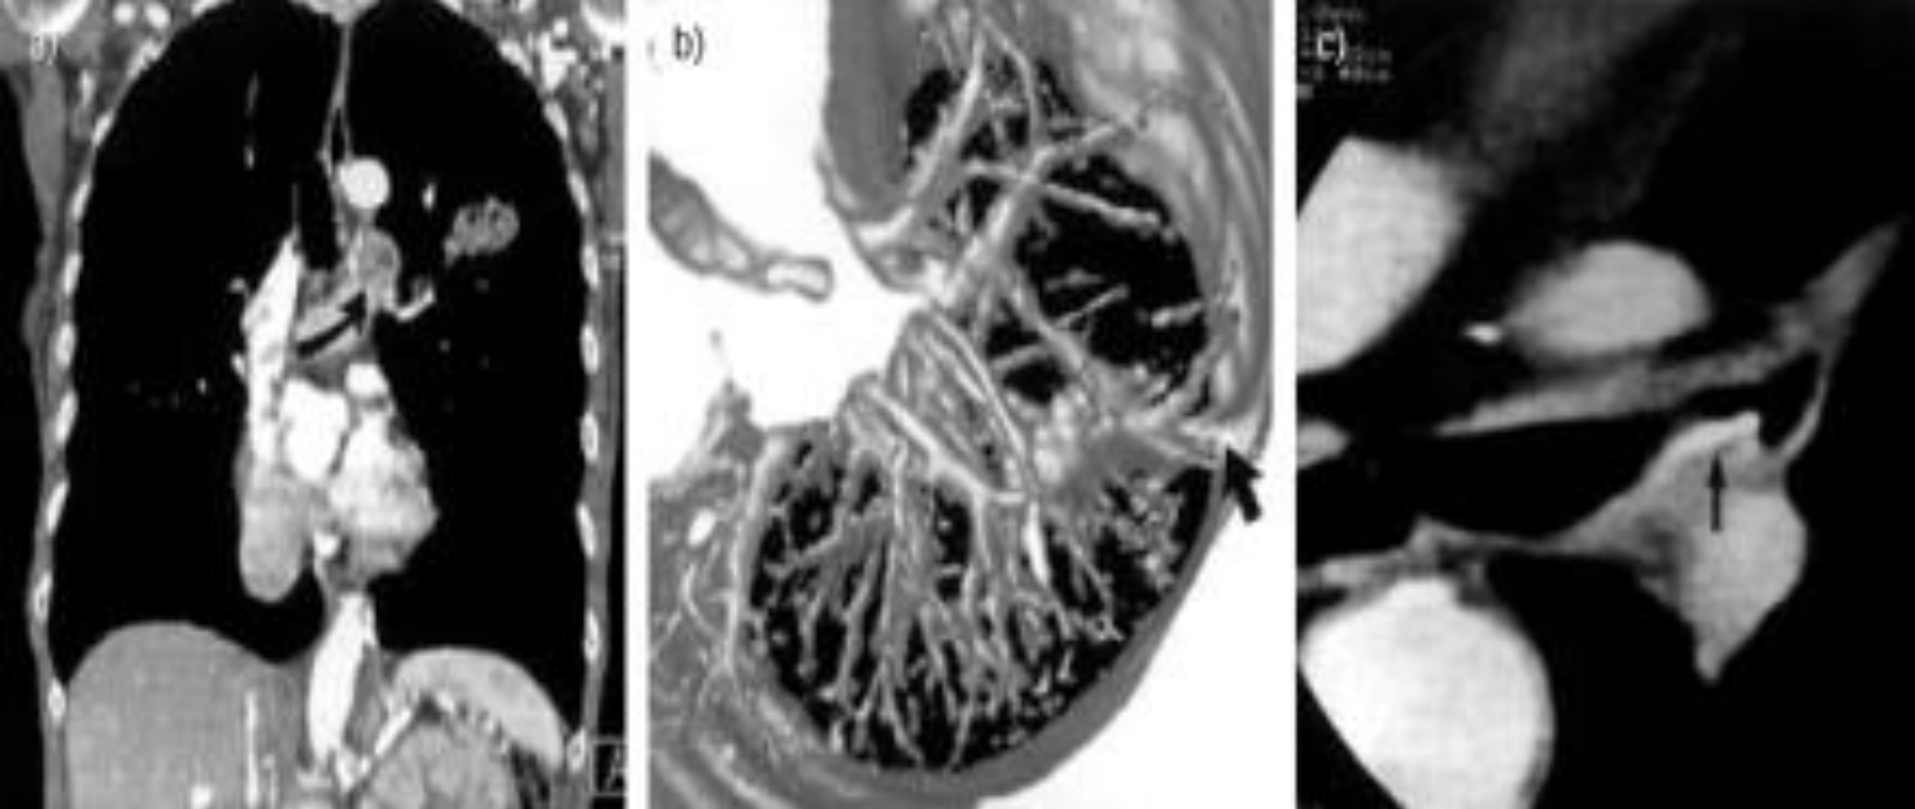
a) Coronal reformat from multislice computed tomography (CT) demonstrating mediastinal lymph nodes (arrow) and a necrotic tumour mass within the lung. b) Three-dimensional-reconstruction of a lung tumour with pleural tag (arrow) c) Thin slice reconstruction in the axial plane from spiral CT data permits the correct identification of an inhaled fish bone (arrow), in a different patient, presumed to be a tumour at bronchoscopy.
